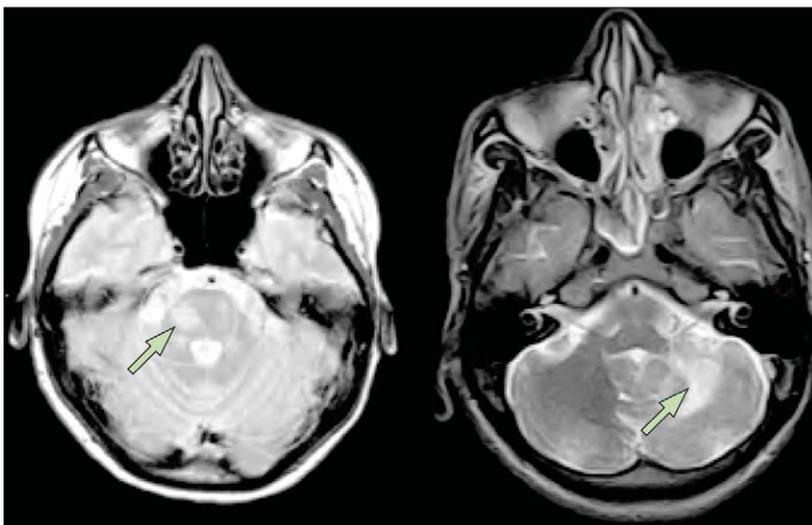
Typical lesion in the posterior fossa in a case of multiple sclerosis (left) and a lesion depicted in a case of PML (right) on T2-weighted scans
